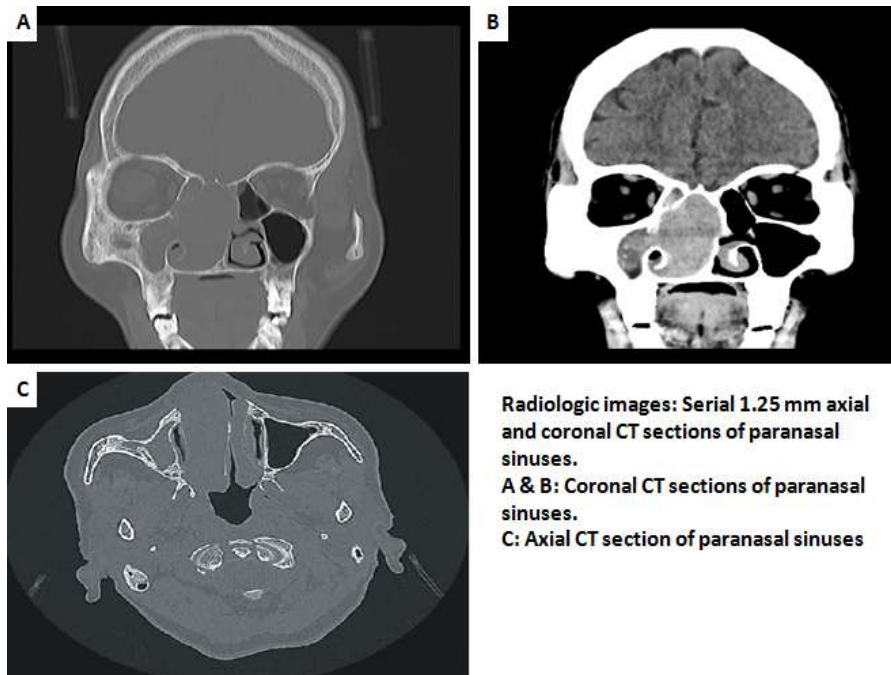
Serial 1.25mm axial and coronal CT sections of the paranasal sinuses showing extensive tumour growth into the right maxillary, ethmoid, frontal, sphenoid sinuses, and the right nasal cavity
